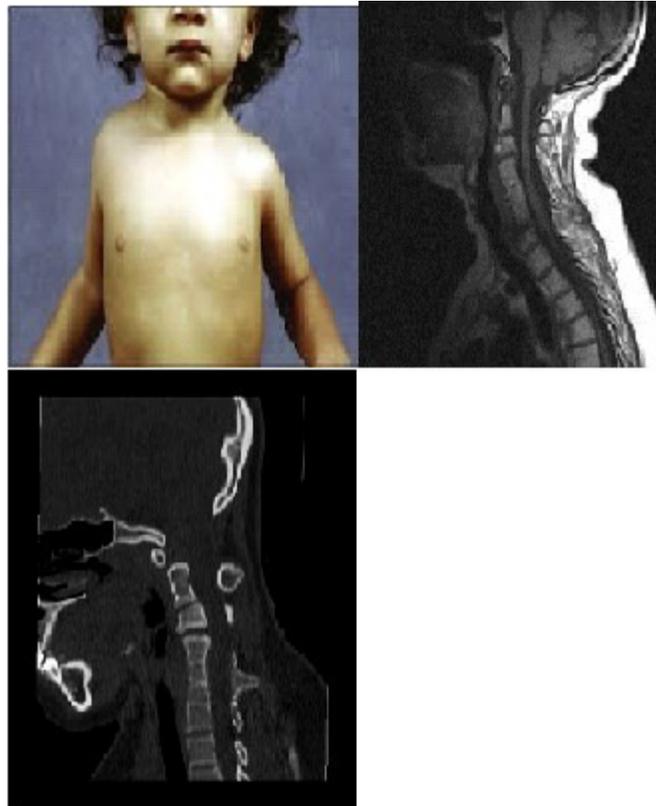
A three year old child with Klippel-Feil Syndrome with right shoulder is up rather than left one. Sagittal MRI and CT Scan display congenital fusion of the vertebral bodies and posterior components of C4 to C7 vertebral. There residues an unnoticeable disc space between the fused vertebrae.
